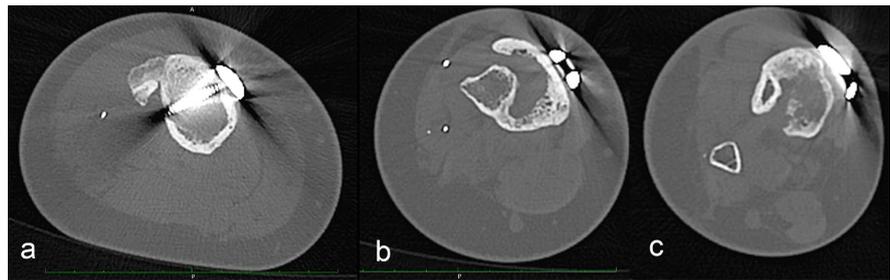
CT images show fusion of the fibula to the proximal tibia (a), fusion of the fibula to the pasteurized tibia segment in the middle third (b) and distally (c).
